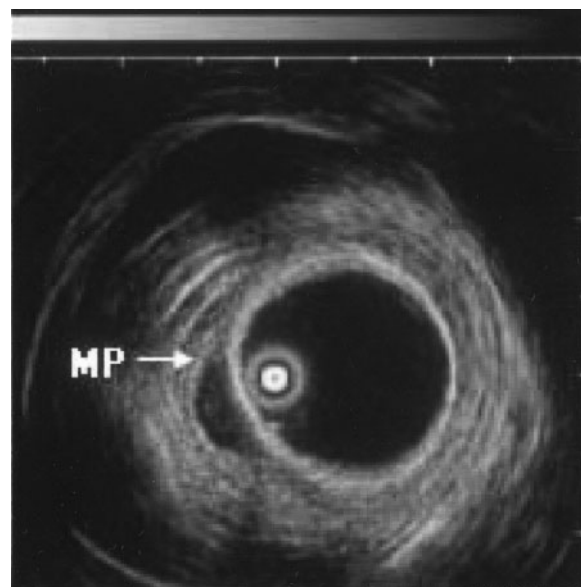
Endoscopic ultrasonography demonstrated a hypoechoic tumor, 13 mm in diameter, located in the submucosa, with clear margins and a smooth contour, with the muscularis propria layer (MP: low echoic layer) intact.
